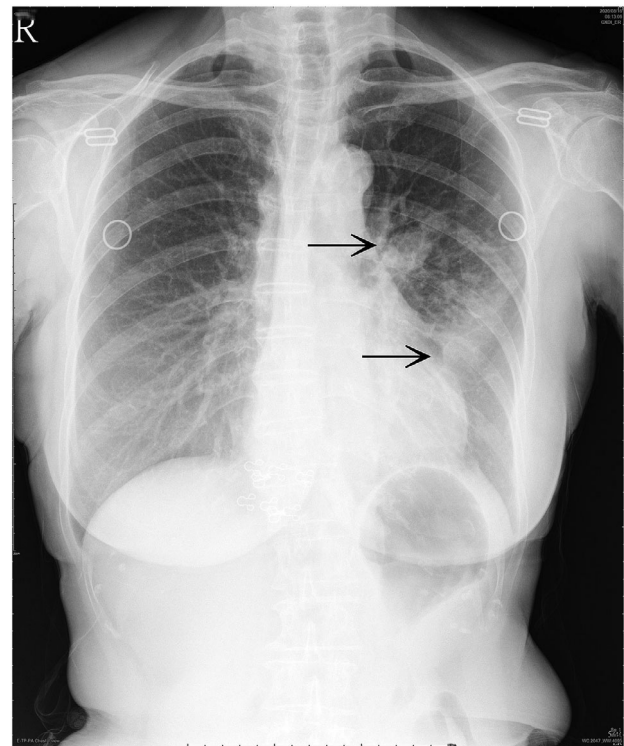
Two ill-defined radiopacities with air bronchogram in the left lower lung (LLL) field and the left hilar region on chest radiograph
